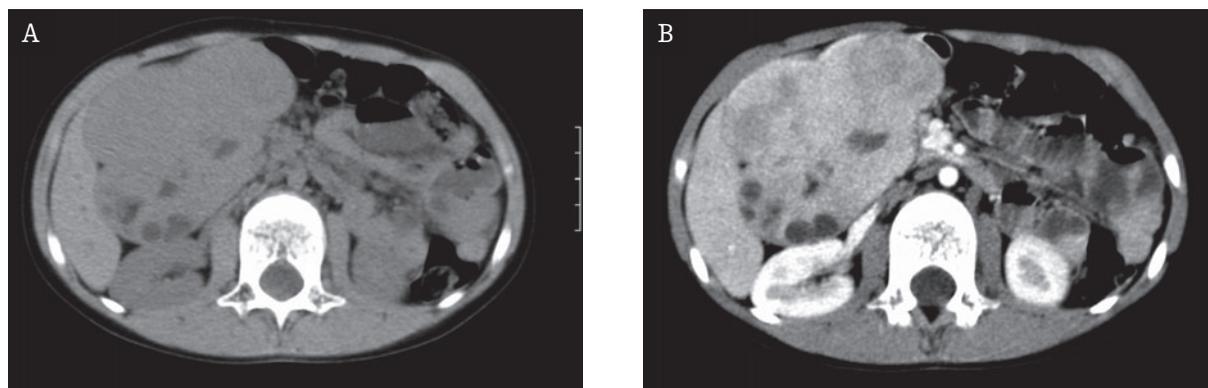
Boy MM. Abdominal CT study before and after contrast medium administration. A polycyclic, non-homogenous, heterogeneously enhancing, well-delineated tumor below the liver hilus.
